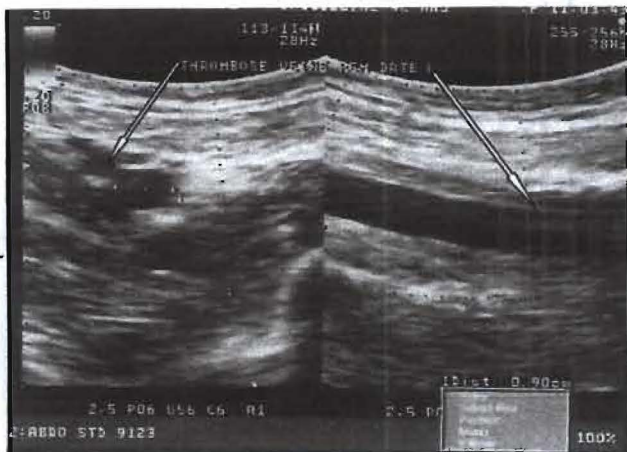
Thrombosis of right femoral vein at Doppler ultrasound (white arrows)
